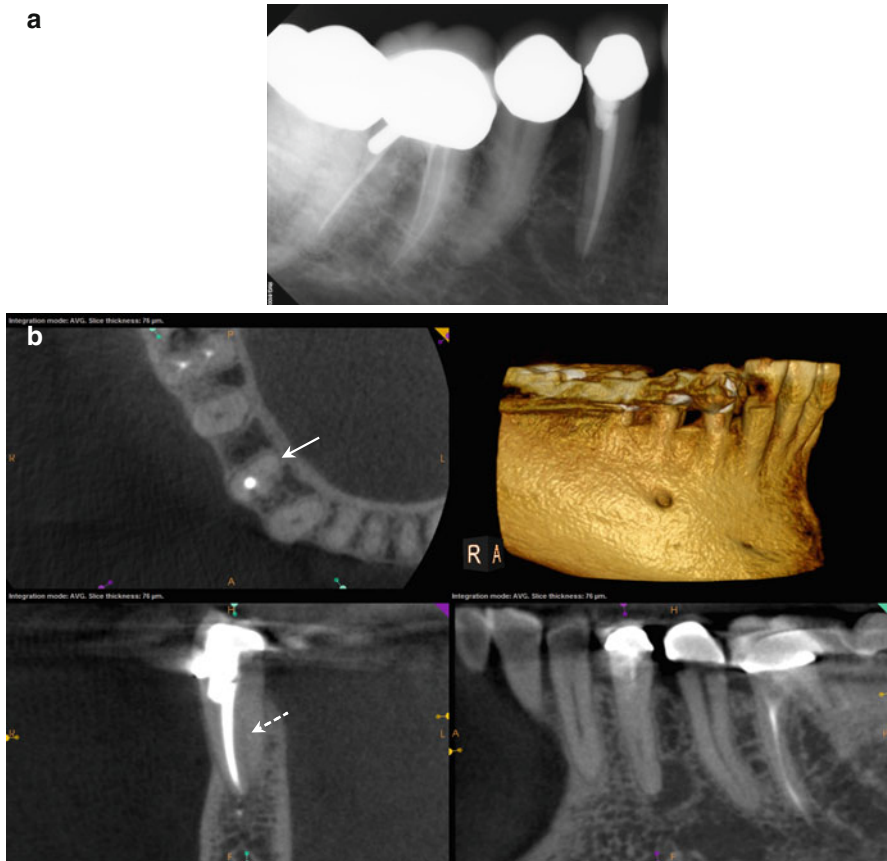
(a) Preoperative radiograph of tooth #28. The tooth has been restored with a full coverage crown, and there is a periapical area at the apex of the tooth. Periodontal probing is minimal, with no deep probing evident circumferentially. The tooth is, however, sensitive to percussion and biting. (b) Survey of the axial sections in the CBCT reveals the asymmetry of the existing root canal filling, highly suggestive of an additional canal space (*white arrow*). A faint low-density line can be seen in the coronal section (*broken white arrows*) bifurcating from the buccal canal at the junction of the coronal and middle thirds of the root. This most likely represents the lingual canal space. (c) The colorized coronal section demonstrates the buccal displacement of the existing obturation; the *yellow arrow* points to the area of the suspected canal location. (d, e) Posttreatment radiographs from different angles, displaying the deep point of the bifurcation (middle third of the root) and sealer extrusions into the periapical area
